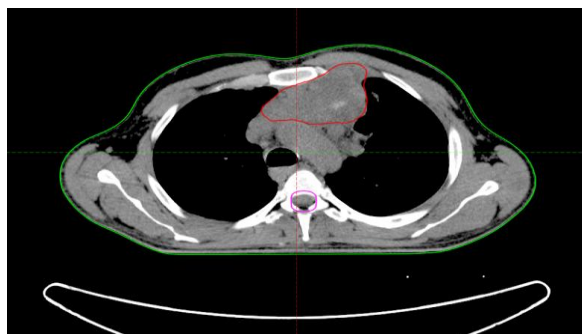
Computed tomography chest showing primary mediastinal seminoma with the involvement of major vessels
